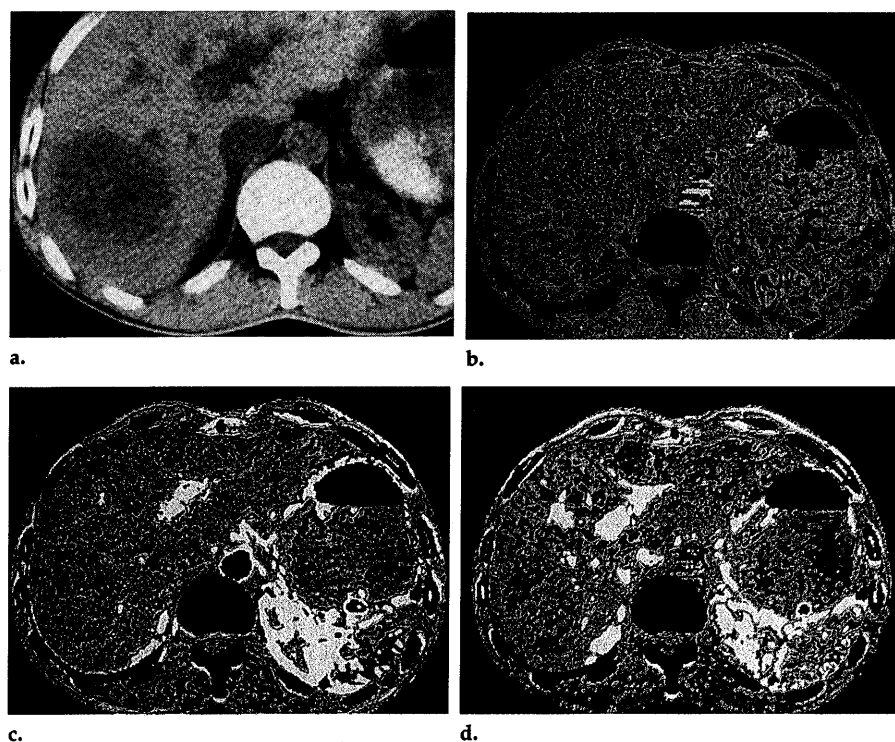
Hepatic metastasis. (a) Unenhanced CT scan, (b) HPI image, (c) arterial perfusion image, and (d) portal perfusion image. Note high arterial and low portal perfusion in the metastasis in the right lobe. The remainder of the liver also demonstrates an increased HPI.
